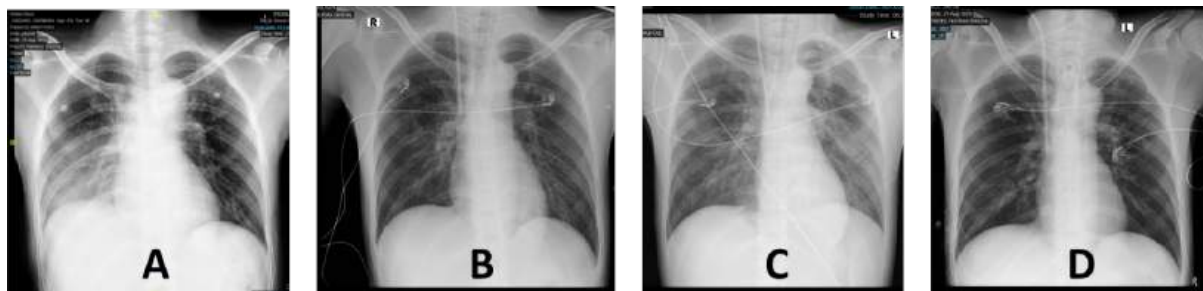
Thoracic X-ray of the patient during treatment (A) day 1 on admission to the emergency room showing right pneumonia (B) day 2 in ICU showing improvement (C) day 8 in ICU showing bilateral pneumonia (D) day 1 showing improvement.
